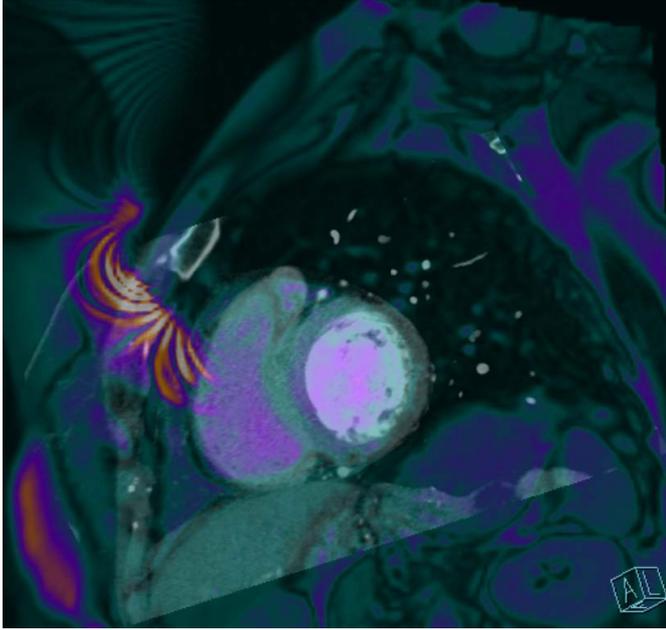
Hybrid CCTA/CMR image with CMR reconstruction superposed on the CT image, revealing anterolateral myocardial ischemia with myocardial scar
